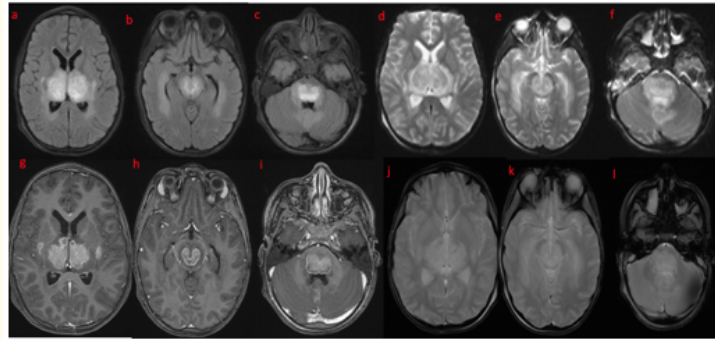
Control MRI 10 days later showing an increase in the previously described lesions.
